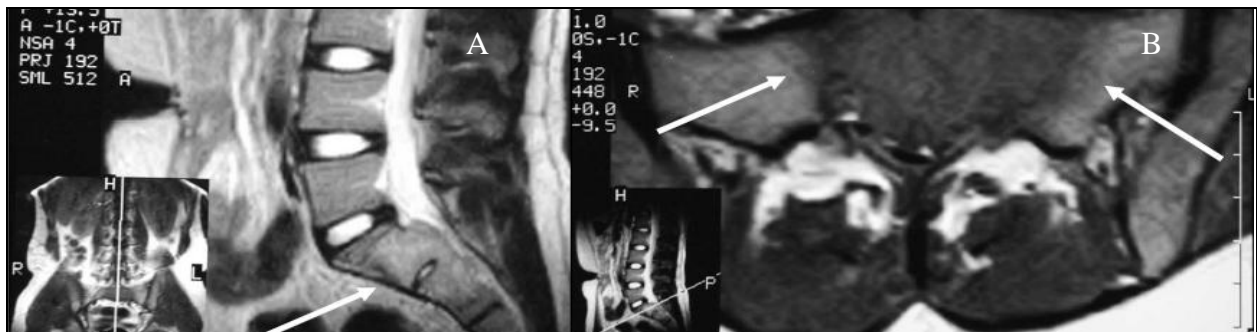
(A, B). Sagittal T-2 (A) and axial T-1 (B) weighted images from initial MRI scan showing expansile tumour (arrows) involving sacral segments S1 and S2 and bulging into the neural canal
